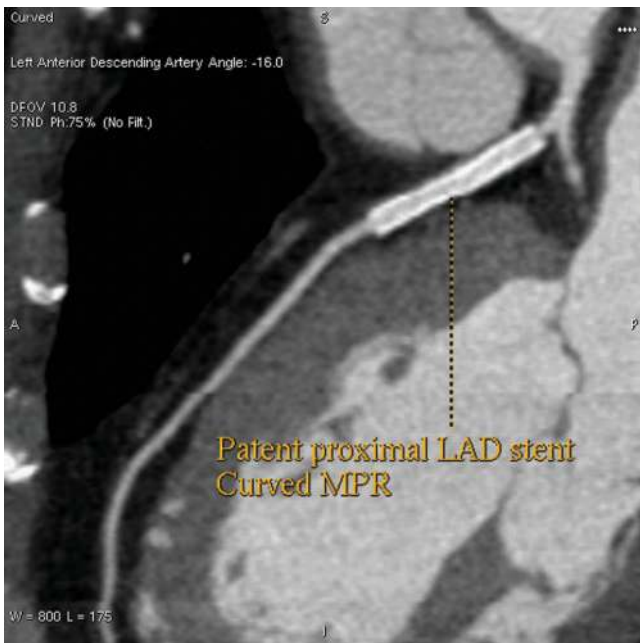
Coronary CT angiography of a patent stent. A patent coronary stent is noticed in the proximal left anterior descending (LAD) artery on a curved multiplana reformatted (MPR) image with clear demonstration of the intrastent lumen without in-stent restenosis.
